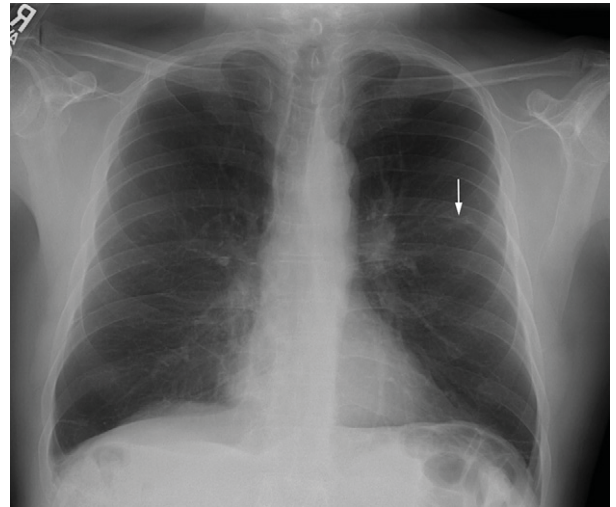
Posterior-anterior chest radiograph shows small left upper lung nodular opacity (arrow) and left hilar prominence.
